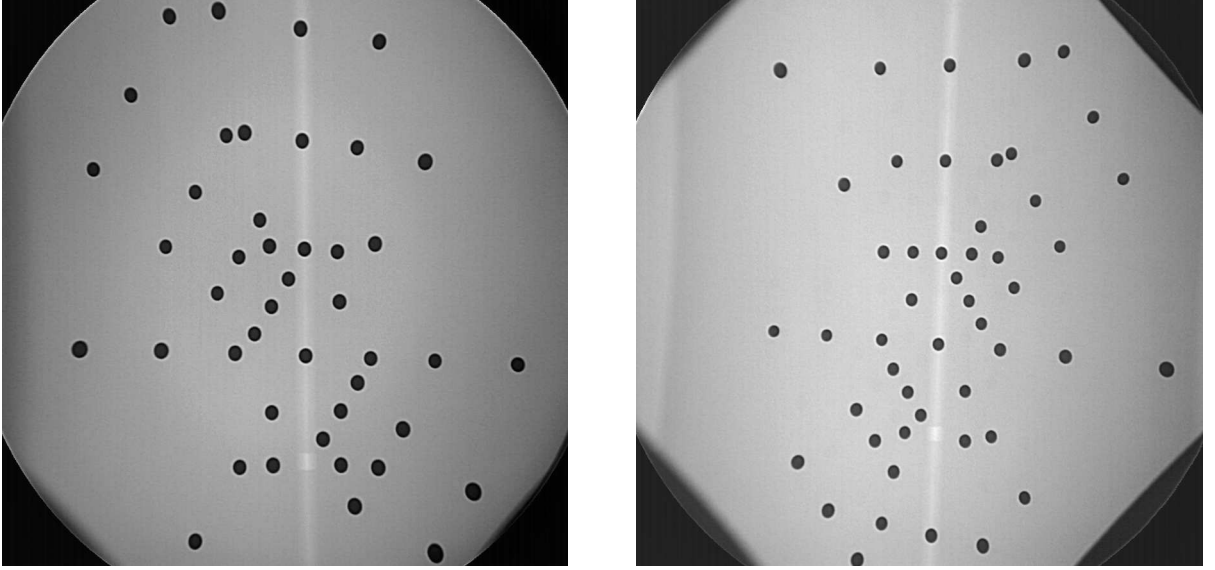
X-ray images of the fluoroscope calibration target (PA left; lateral right).
